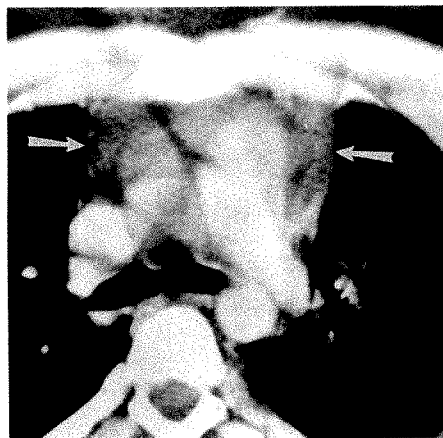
CT shows mediastinal hemorrhage and acute sinus of Valsalva aneurysm.
